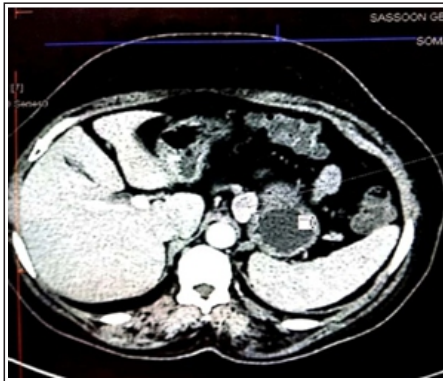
Pre operative CT scan image.
